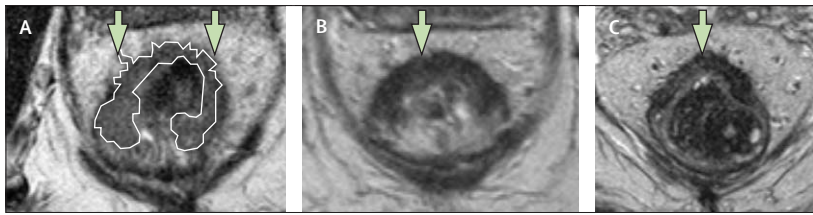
Axial T2-weighted MRI of T3 tumour
